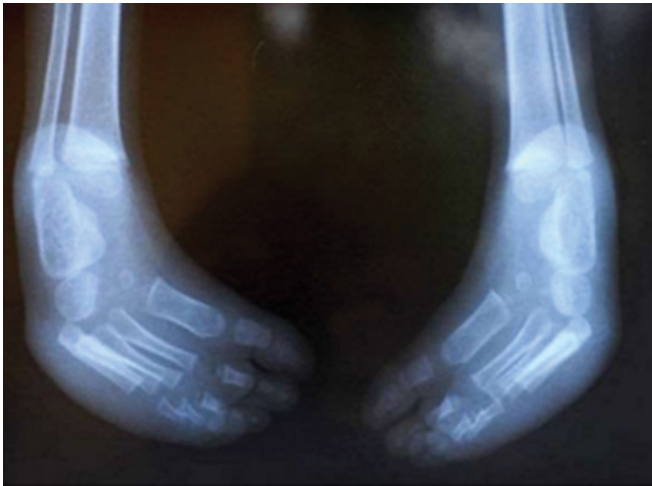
X-ray of infant with bilateral TEV.
